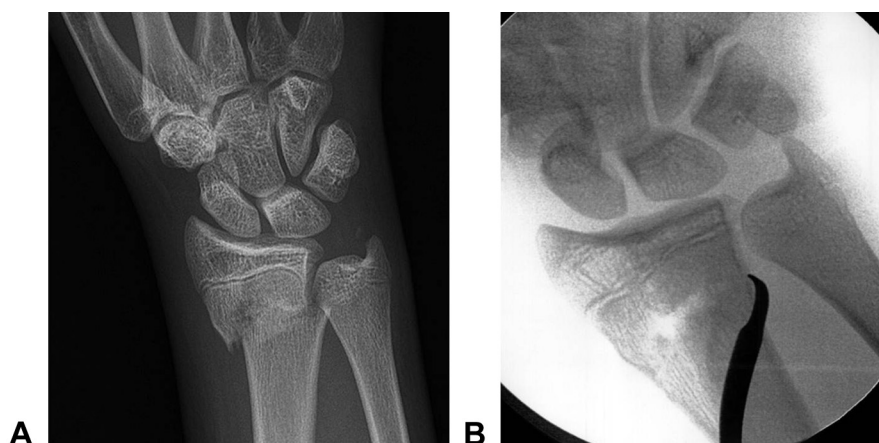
A Preoperative and B intraoperative posteroanterior radiographs demonstrating coronal shift reduction technique involving placement of a Hohmann retractor in the interosseous space.
